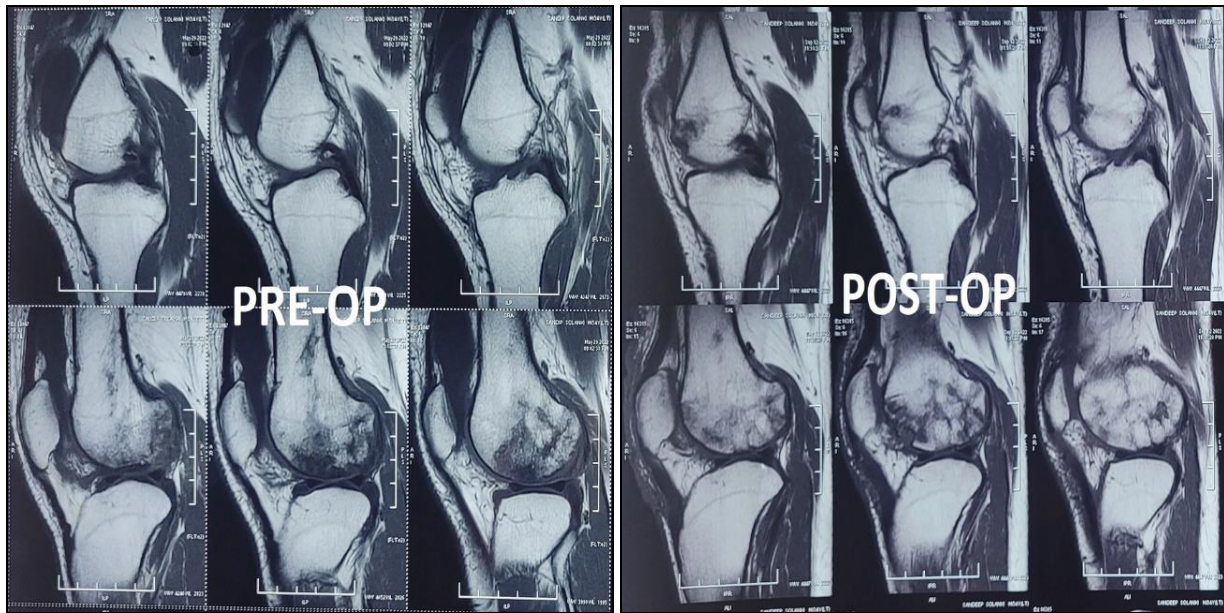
a, b: Image on the left (1a) shows T1 weighted sagittal MRI of preoperative left knee with 'crescent sign' due to subchondral fracture and radiolucency. Image on the right (1b) shows postoperative uptake of osteochondral plugs showing isodensity with the surrounding viable area.
